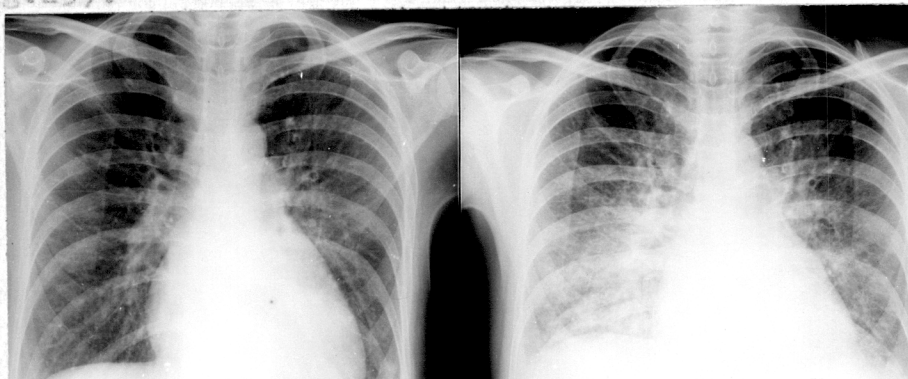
Chest radiograph of Patient number 80 in ventricular tachycardia on the left, and sinus rhythm on the right. Gross pulmonary oedema is shown in sinus rhythm.
